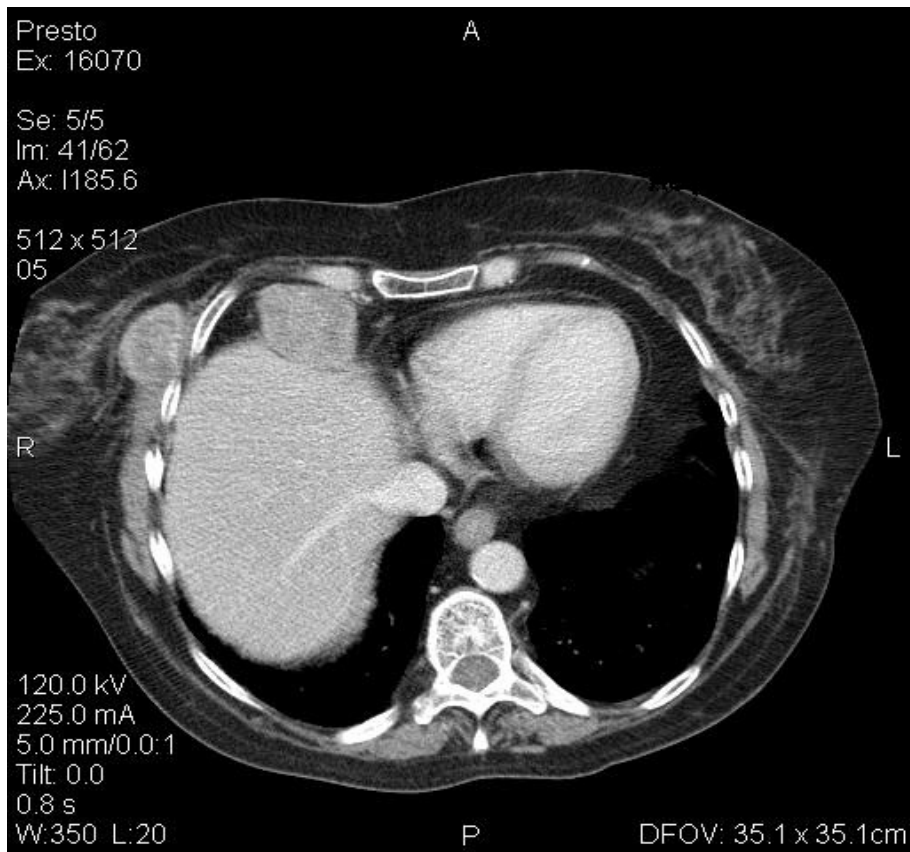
Postcontrast CT, axial section, necrotic liver mass, 3.3cm diameter
